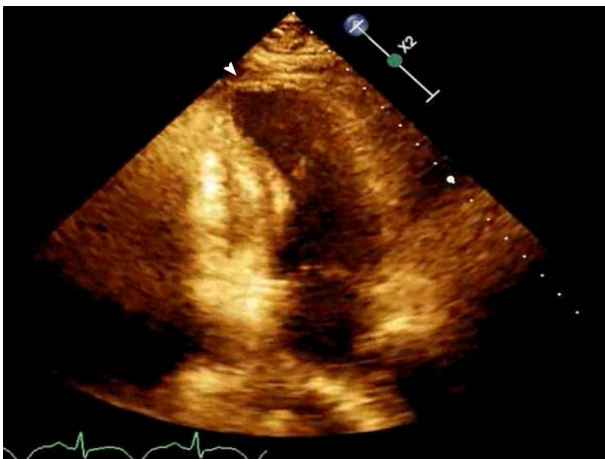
Echocardiogram on HD 16 showing apical ballooning.
